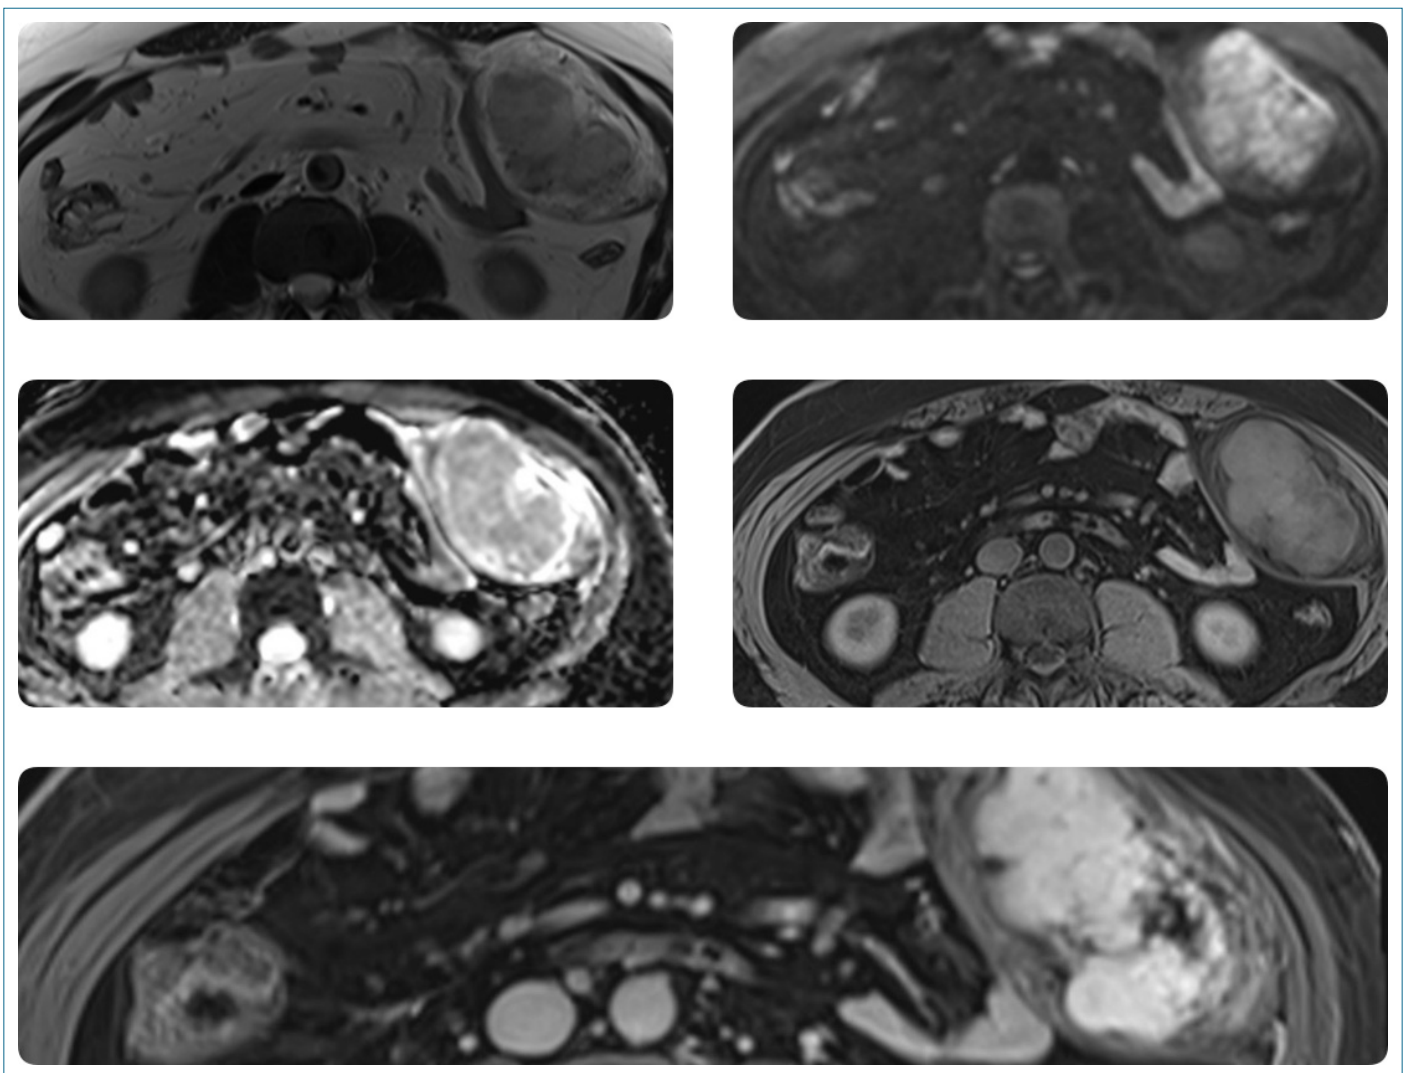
MRI displays a solitary fibrous tumor on a T2-weighted axial image, showing heterogeneously hyperintense areas alongside regions of low signal intensity, creating a white and black appearance within the rectus abdominis muscle on the left hypochondrium. The tumor exhibits hyperintensity on diffusion-weighted imaging and restriction on apparent diffusion coefficient (ADC) mapping, with progressive enhancement observed during the arterial, portal venous, and delayed phases.
